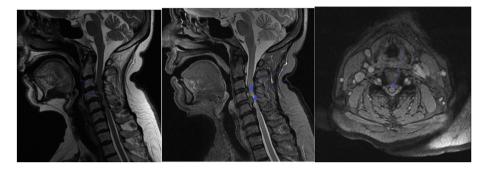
sagittal (STIR and T2) and axial MRI imaging shows degenerative disk herniation in C3/4/5/6 levels.
